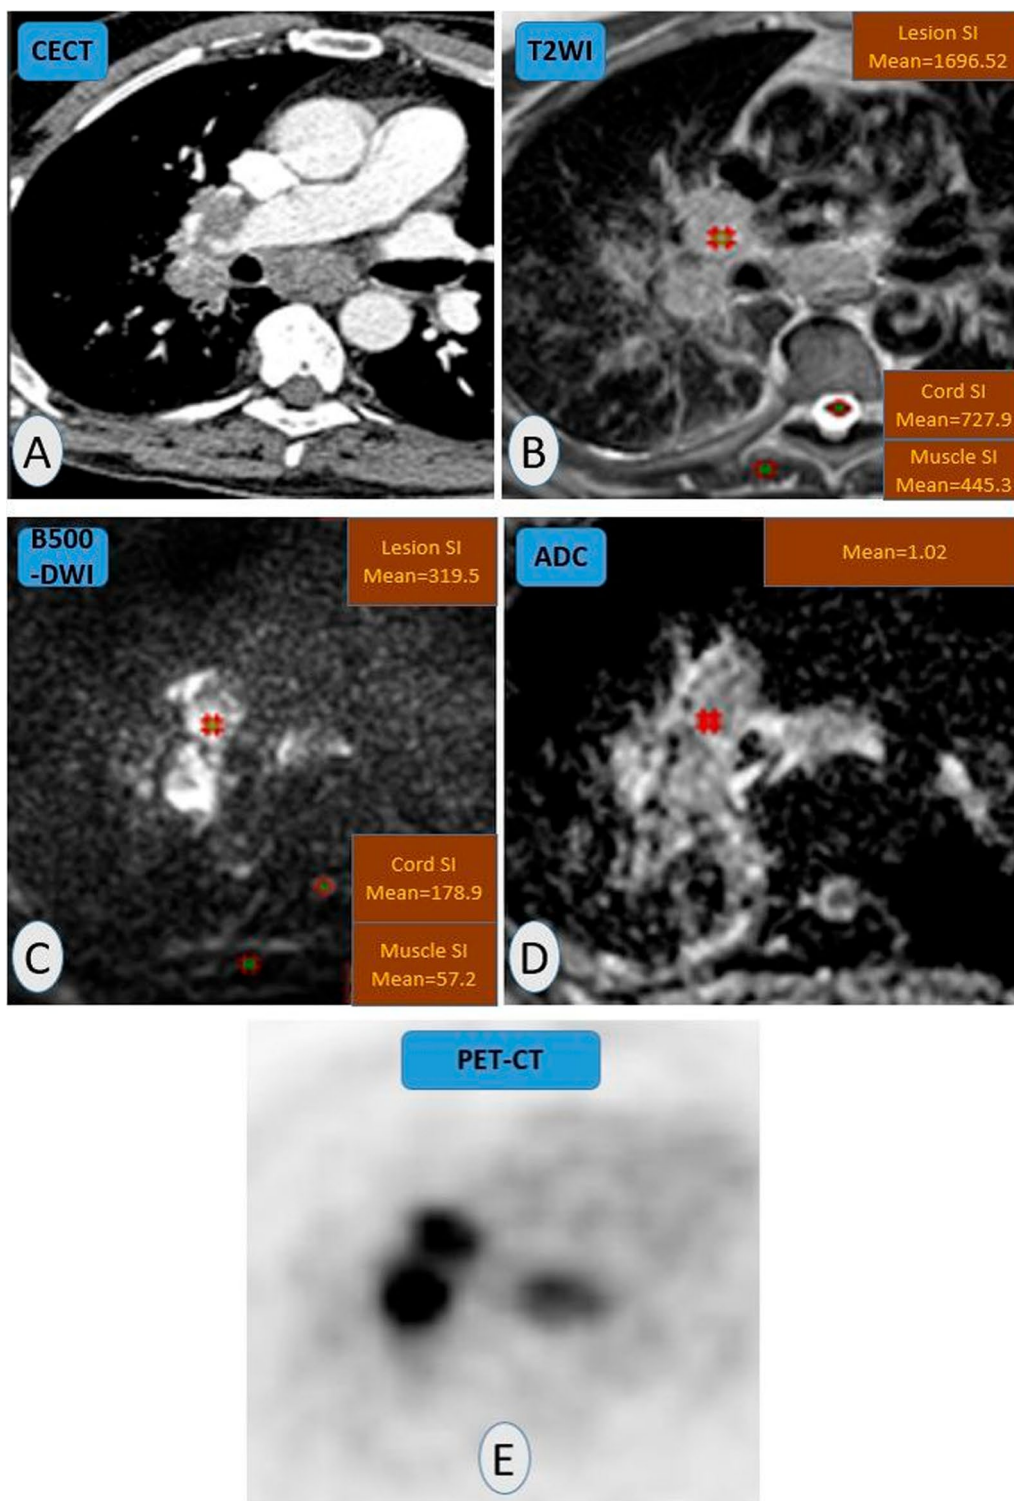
A 65 years-old-male patient with pulmonary adenocarcinoma. A Contrast-enhanced chest CT showed two right hilar and single sub-carinal globular hypo-enhancing lymph nodes. B T2WI-MRI showed a homogeneous hyper-intense signal (compared to muscle signal) with lesion-to-cord signal ratio=2.3 and lesion-to-muscle signal=3.8. C b500-DWI showed a bright signal with lesion-to-cord signal ratio=1.8 and relative contrast ratio=4.5. D Mean ADC value= $1.02 \times 10^{-3} \text{ mm}^2/\text{s}$ (positive restriction). E PET-CT examination with high FDG uptake (hot spot) ... Pathologic proven metastatic lymph node
